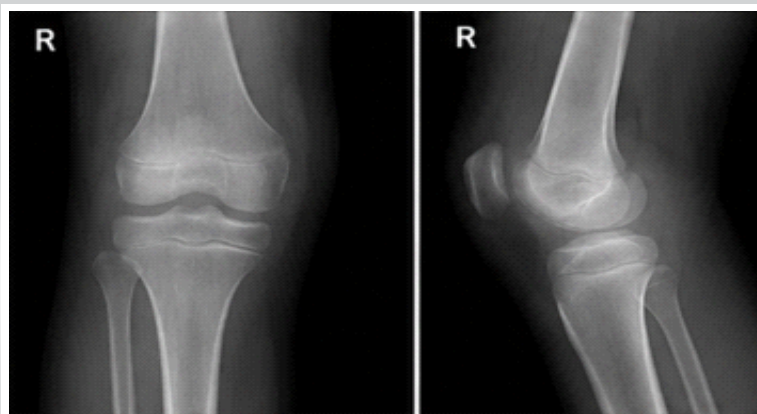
Post-operative radiographs (anteroposterior and lateral views) after arthroscopic washout showing reduced joint effusion and maintained joint space without bony destruction.
